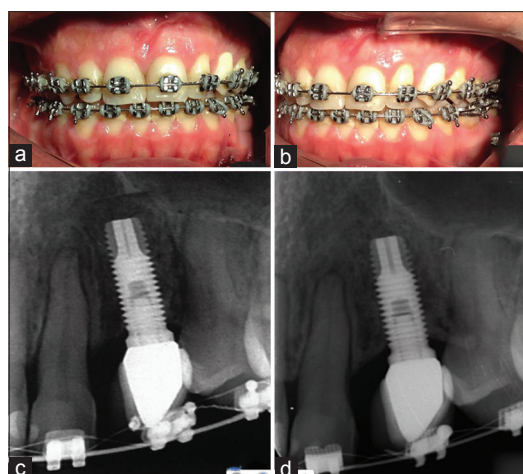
(a and b) Clinical aspect 16 months post-operatively, (c and d) comparison of immediate and 16 months post-operative radiographic records.
